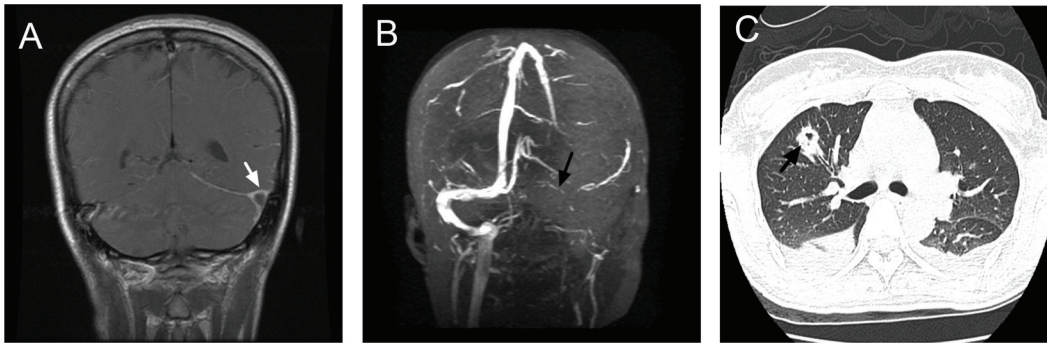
Imaging of a patient with periodontitis who developed cerebral sinus thrombosis and pulmonary embolism. (A) Gadolinium-enhanced T1-weighted magnetic resonance image reveals filling defect in the left transverse sinus, indicating thrombus formation within the dural sinus. (B) Magnetic resonance venogram shows absence of flow signal in the left transverse and sigmoid sinuses and internal jugular vein. (C) Chest computed tomography shows multiple pulmonary nodules with cavitation, which is compatible with septic emboli.
